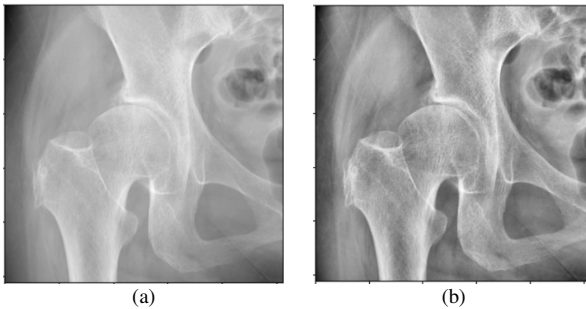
Hip X-ray: (a) Original image, (b) CLAHE image.
